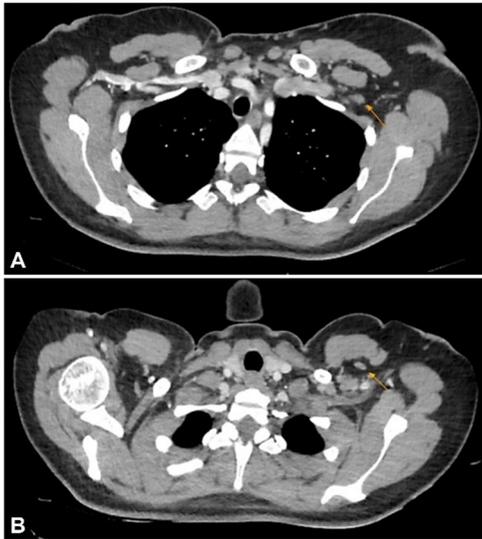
CT coronal sections showing axillary (A) and retrosternocleidomastoid (B) lymphadenopathy, respectively.
